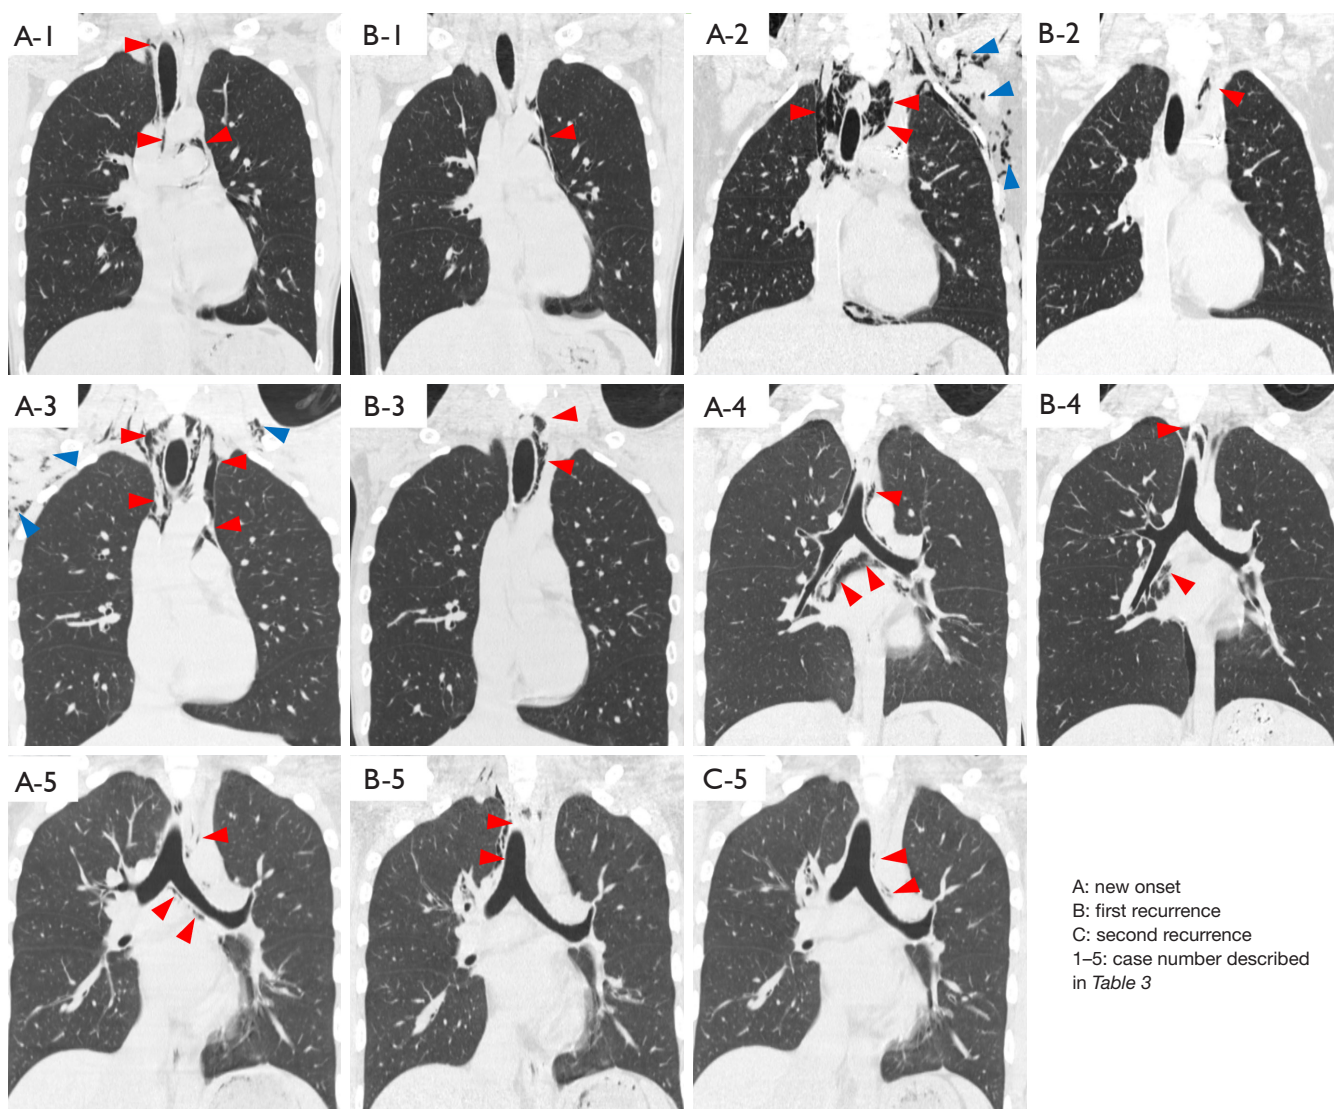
Coronal images of chest computed tomography scans at the onset and recurrence of SPM. The number corresponds to the case number described in *Table 3*. (A) Coronal image of new-onset SPM. (B) Coronal image of the first recurrence. (C) Coronal image of the second recurrence (only case 5). All images showed free air accumulation in the mediastinum (red arrowheads). In cases 2 and 3, subcutaneous emphysema (blue arrowheads) was seen only with new-onset SPM (A); it was not seen with recurrence (B). In all five cases, the degree of free air accumulation was similar to or less aggressive during recurrence (B) than that observed with new-onset SPM (A). SPM, spontaneous pneumomediastinum.
